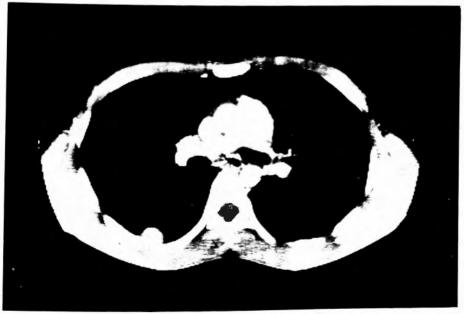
CT showed the tumor as a chest wall tumor.
